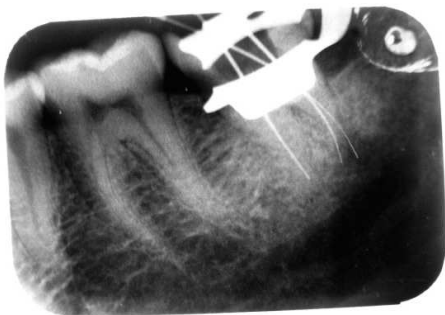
Radiographic confirmation of extracanal and foramen in the extra distal orifice
